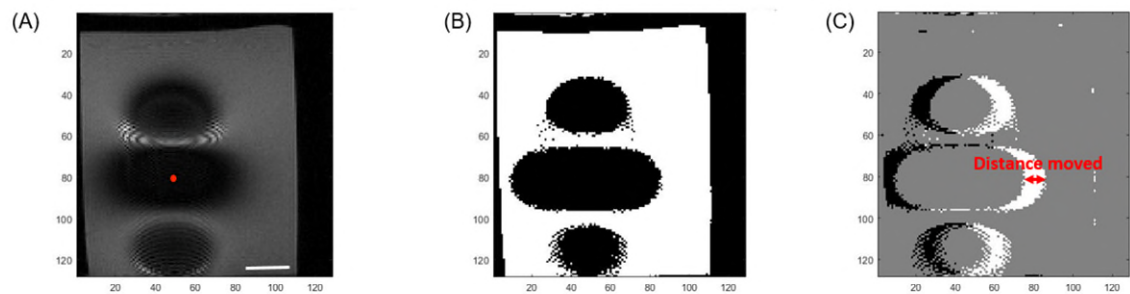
MR image of a 0.5 mm magnetic seed. (A) Gradient echo image of the seed in agar sample. Approximate location of the seed is indicated using the red circle. Large susceptibility effect apparent in the image as a result of the magnetic distortion produced by the seed. Scale bar 5 mm. (B) Binary image of the same 0.5 mm seed produced using Otsu's method in MATLAB. (C) Image produced by subtracting the binary image before the movement from the after image. Distance moved measured as indicated in the figure.
